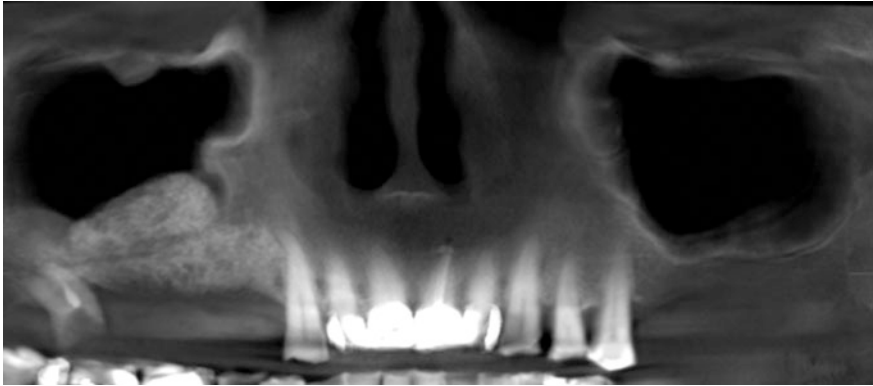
CBCT “panorex” shows the region of interest for dental implant planning
